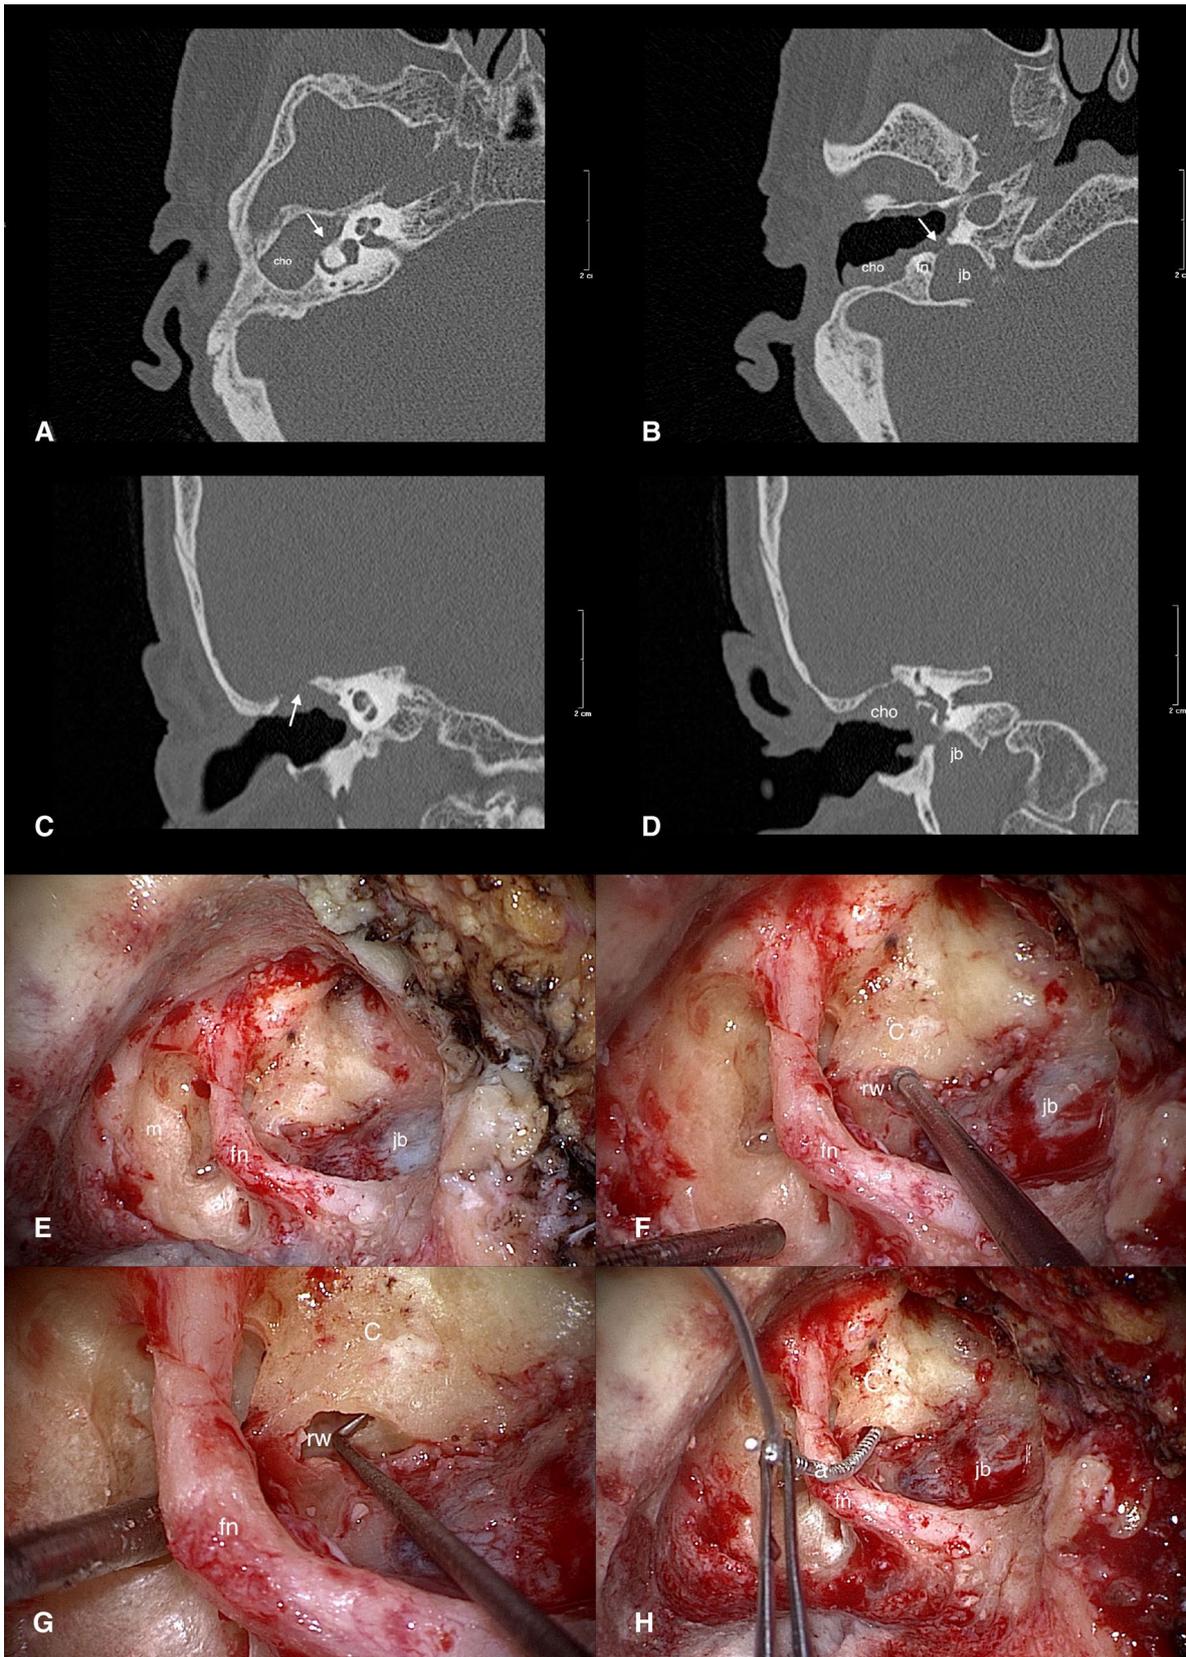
Preoperative CT scan. Subtotal petrosectomy, and translabyrinthine approach with placement of a cochlear implant. Right ear. a Recurrence of cholesteatoma (cho) completely invading the cavity of the earlier mastoidectomy. Fistula in the lateral semicircular canal (white arrow). b Cholesteatoma (cho) invading the tympanic portion of the facial nerve (fn). Dehiscence of the jugular bulb (jb). Fistula in the lateral semicircular canal (white arrow). c Interruption of the tegmen tympani (white arrow). d Cholesteatoma (cho). Dehiscence of the jugular bulb (jb). e After the subtotal petrosectomy and labyrinthectomy (m), the third segment of the facial nerve (fn) is completely skeletonized and the jugular bulb exposed (jb), appearing partially dehiscence. f, g Identification of the cochlea (C) and the round window (rw) and cochleostomy. h Insertion of the array (a)
